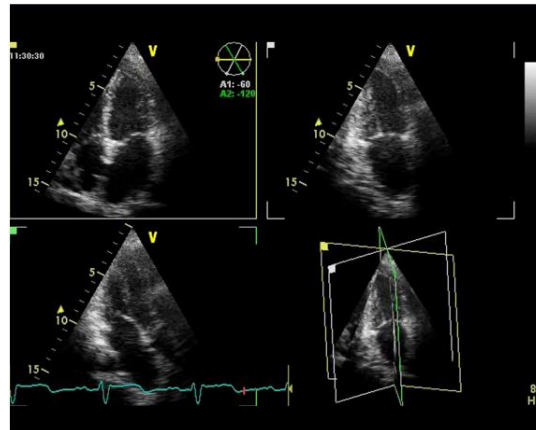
Post-operative echocardiogram did not show any residual tumor.
